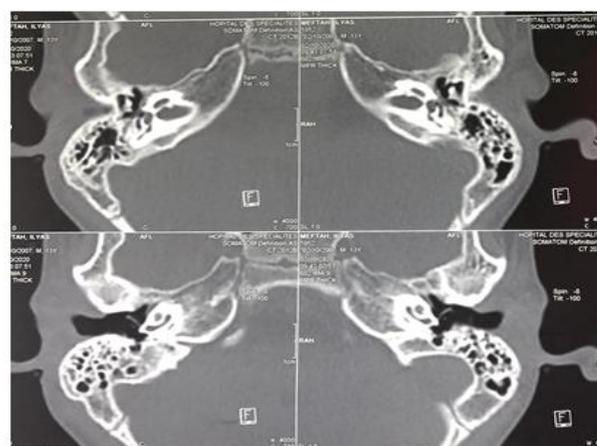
Axial & coronal temporal bone CT cut
